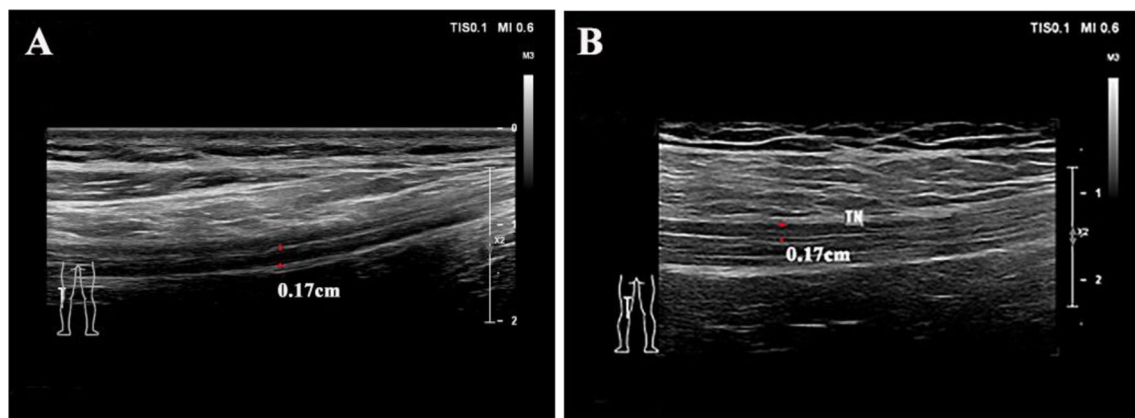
(A) Ultrasound of the left common peroneal nerve showing a thickened segment of the nerve bundle, measuring approximately 0.17 cm in thickness and located in the popliteal fossa. (B) Ultrasound of the left tibial nerve also revealed a thickened segment of the nerve bundle, which was approximately 0.17 cm thick, in the popliteal fossa
